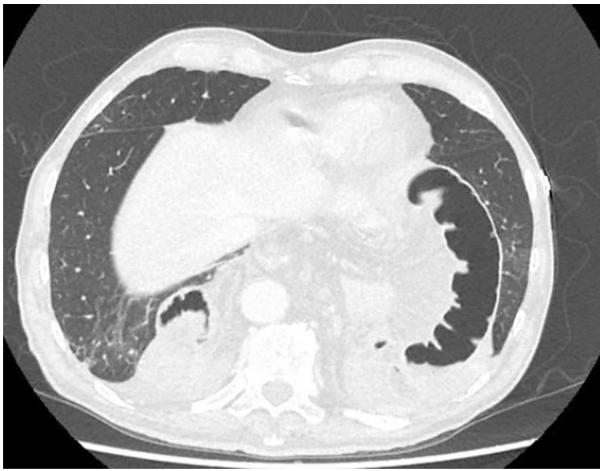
CT-scan with small intestine loops in both hemithorax.
